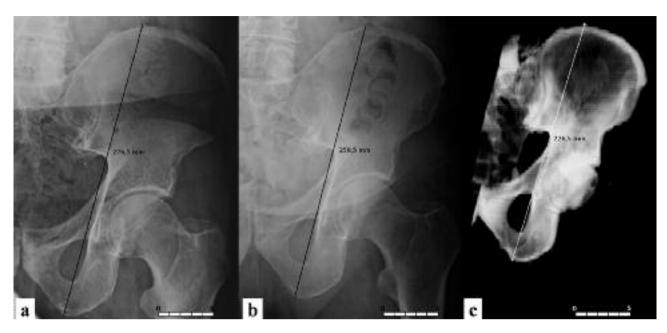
Three different views from the same patient. Note that the scale bar (5 cm) has the same size in the three documents. Using the CT scan as reference value (1c), magnification was calculated as being 122% for the first radiograph (1b), and 114% for the second radiograph (1b).
